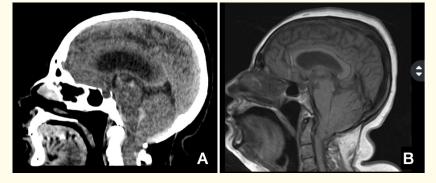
A.-Sagittal section tomography shows descent of the cerebellar tonsils >5mm. With absence of the cisterns of the base and occlusion of the fourth ventricle B: T1-weighted magnetic resonance imaging, sagittal section corroborates descent of the cerebellar tonsils and obliteration of the fourth ventricle.
